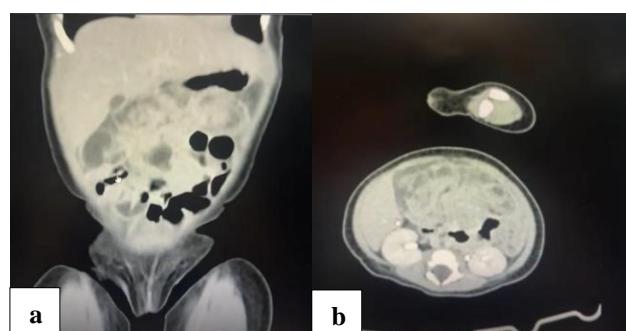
(a and b): CT images of the baby revealing persistent ileocolic intussusception without any evidence of bowel gangrene.
